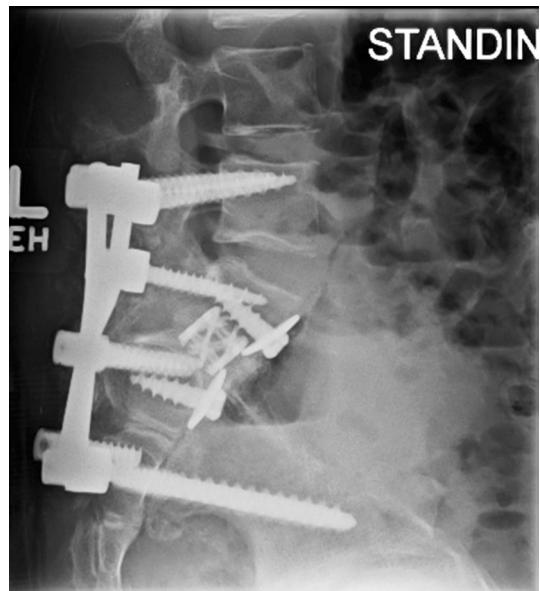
Lateral radiograph after placement of anterior interbody cage at L5-S1. Reproduced with permission from the Children’s Orthopaedic Center, Los Angeles
